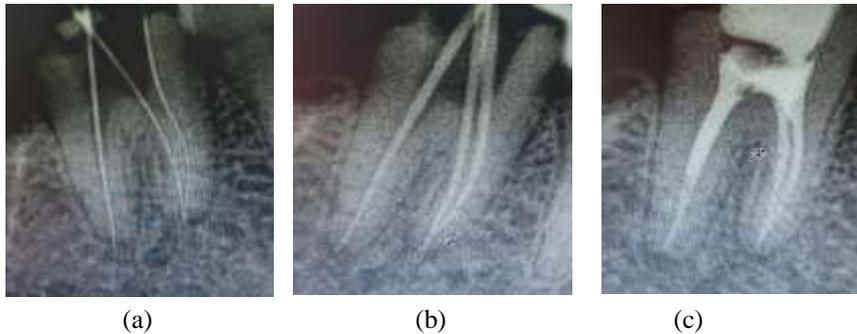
Radiograph showing Working Length (a), Master cone (b) and Obturation (c) of tooth no. #47.
